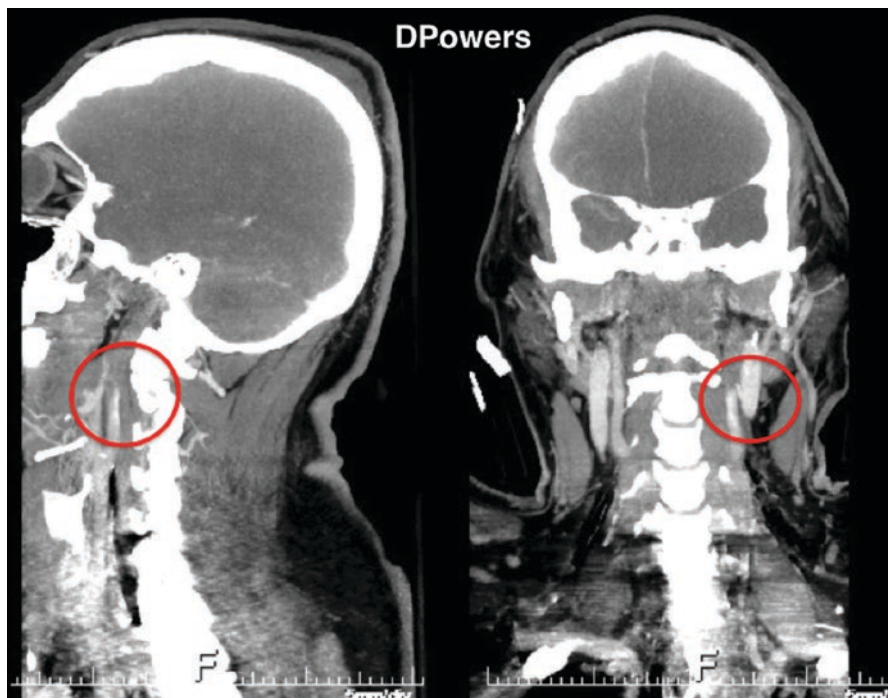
A CT angiogram of the neck in a patient with a penetrating injury transecting the internal carotid artery
